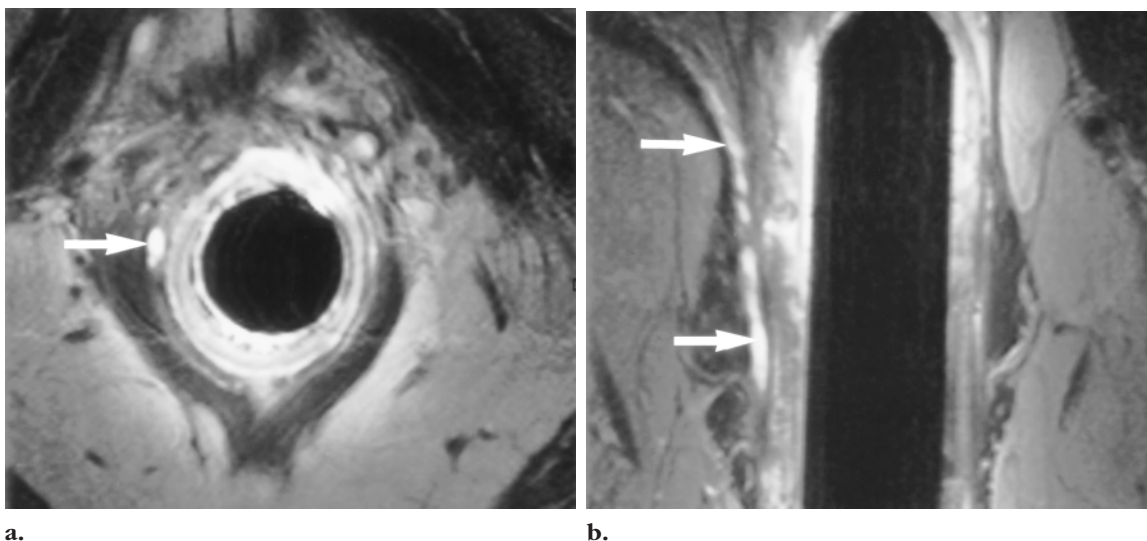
(a) Axial T2-weighted turbo spin-echo (2,500/100) MR image shows a hyperintense structure (arrow) in the intersphincteric space that may represent a fistula. (b) On a coronal slightly oblique T2-weighted turbo spin-echo (2,500/100) MR image, the hyperintense structure in the right lateral aspect of the intersphincteric space (arrows) has a very thin wall and a lobulated, serpiginous aspect. This structure is a vein and not a fistula. The vein is continuous with the periprostatic veins. Compare this case with the perianal fistula shown in Figure 10b, which has a straighter course, a thicker wall, and no connection to vascular structures.
